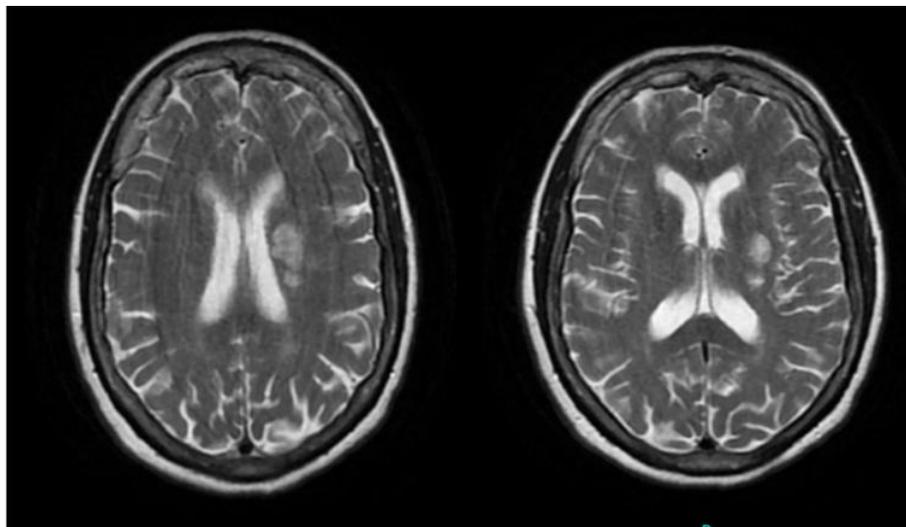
MRI brain showing focal area of acute or subacute ischemia left basal ganglia
